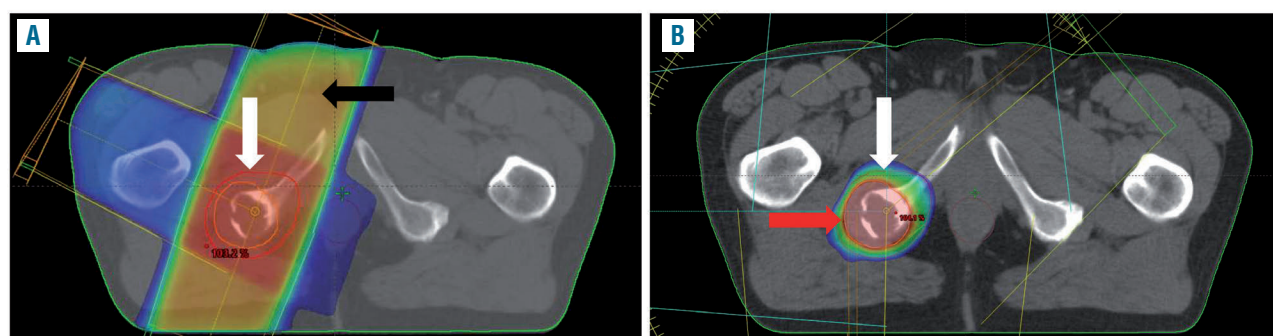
Planning computed tomography scanning of a myeloma lesion in the right ischium. The dose distribution is depicted by a color wash from red (= high dose) to dark blue (= low dose). (A) Conventional technique: 50 Gy in 20 fractions of 2.5 Gy to complete target volume. Black arrow: areas of high dose out of target volume (red line/white arrow). (B) Volume modulated arc therapy (VMAT) technique. Red line/white arrow: main target volume 40 Gy in 20 fractions of 2.0 Gy; orange line/red arrow: integrated boost target volume 50 Gy in 20 fractions of 2.5 Gy. The complete dose of each fraction is delivered simultaneously integrated to both target volumes.
